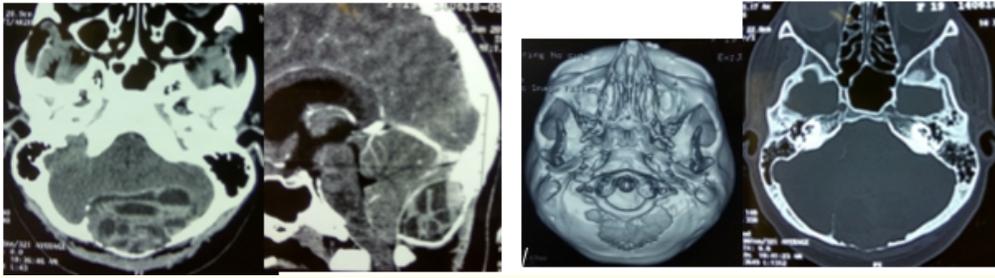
Shows CT SCAN of brain showing aneurysmal bone cyst in occipital region with soap bubble appearance and bony destruction.
